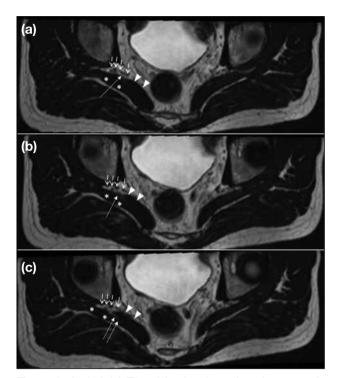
(a-c) Axial T2-weighted turbo spin echo magnetic resonance imaging (repetition time: 3120 ms, echo time: 77 ms), from superior to inferior. Aberrant muscle fibres of the piriformis muscle (arrowheads) are noted anterior to the main bulk of the piriformis muscle (asterisks). The common peroneal division of the sciatic nerve (long arrows) passes between the main bulk and aberrant muscle fibres of the piriformis muscle. Short arrows denote tibial division of the sciatic nerve.
